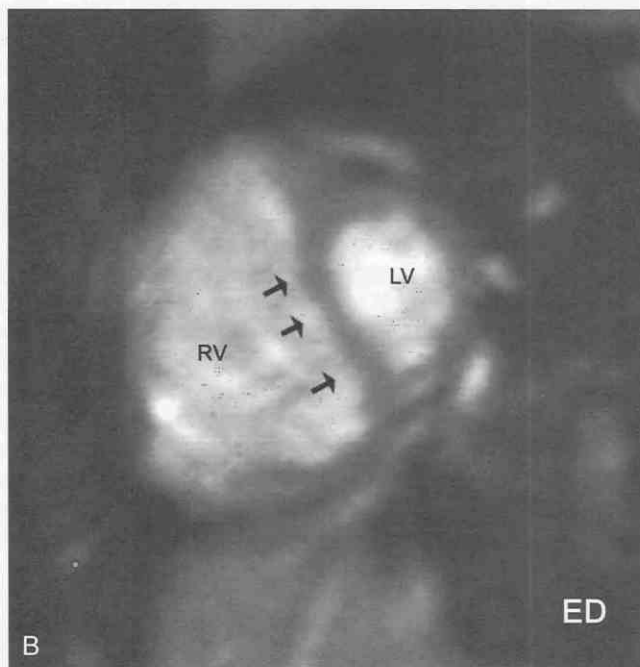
MR image obtained from a 6-year-old girl with primary pulmonary hypertension and right ventricular dysfunction.
